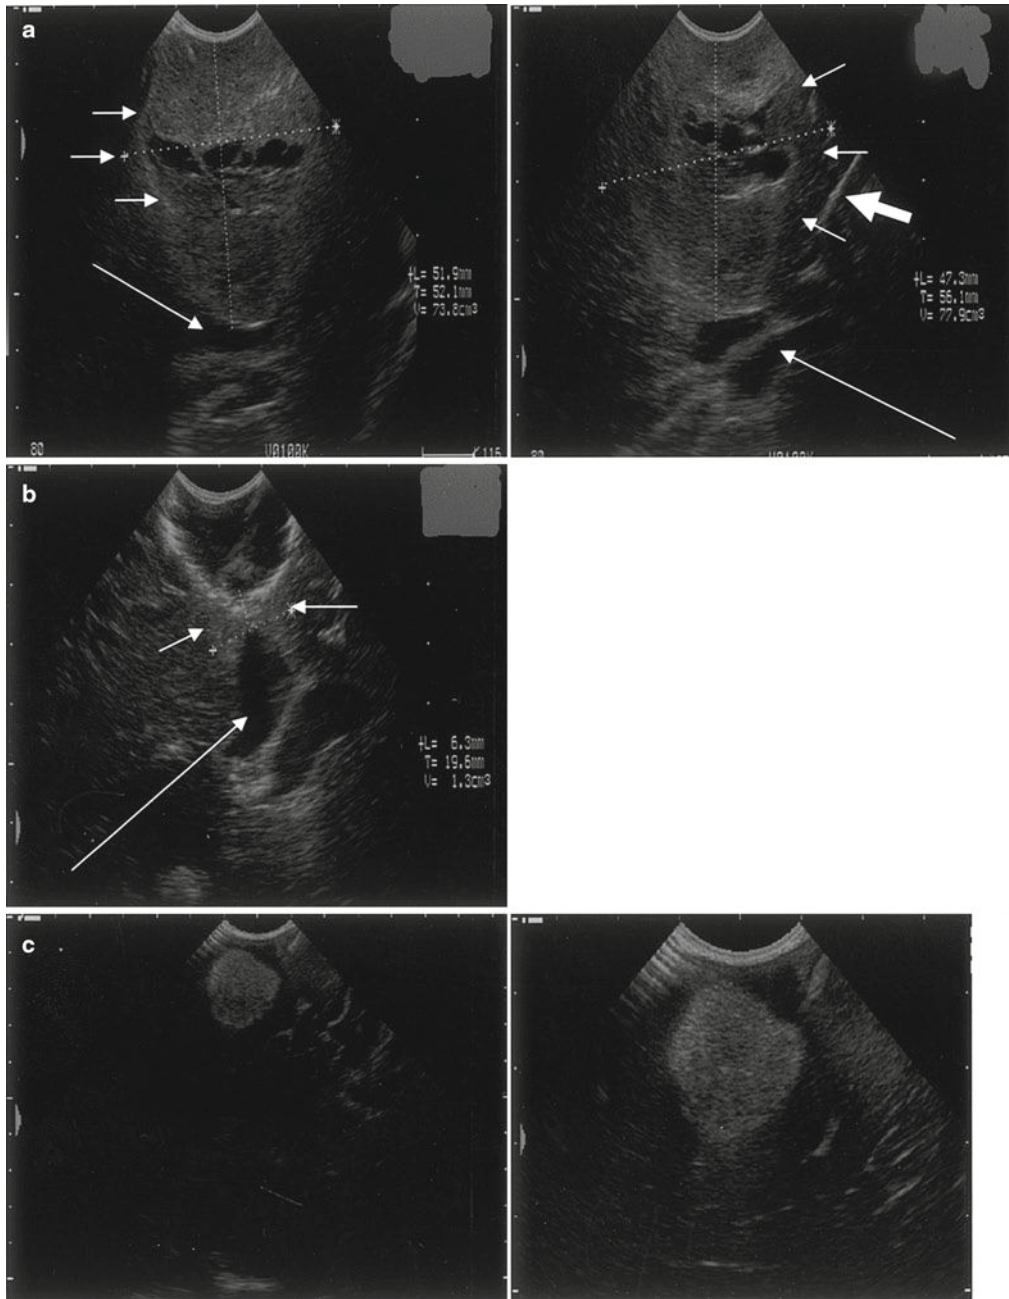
(a) A right frontal located glioblastoma multiforme in two different planes of insonation; the small *arrows* show the relatively sharp defined margine zone of this tumor. Compared with the surrounding tissue the echogenicity of this tumor ranges from moderate hyperechoic to anechoic in the center as a result of central cysts. Both anterior horns of lateral ventricles are compressed (*long arrows*). On the right picture the thick arrow points out the shifted interhemispheric fissure. (b) As a result of relief due to tumor removal the anterior horns get their normal extend (*long arrow*). Because of infiltration of the internal capsule and the corpus callosum a small rest of tumor was left (*small arrows*). (c) Left picture shows a typical ultrasound feature of a metastasis during the first screening with a selected large image field. Compared to the surrounding tissue the tumor has a well defined and strong elevated homogeneous echoic pattern. Picture on the right shows the same tumor with a higher resolution due to selection of a lower image field
